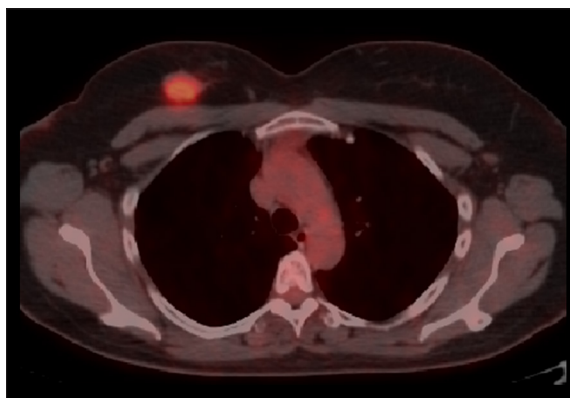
Axial FDG-PET/CT image of a right-sided breast cancer mass in a non-LABC patient without axillary lymph node metastases. Tumoural SUV_{max} was 5.0.
